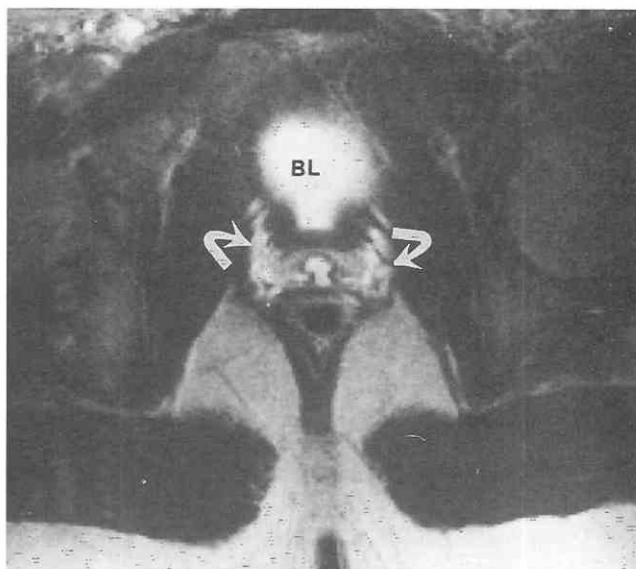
Normal male pelvis. Transaxial T2-weighted fast spin-echo MR image (2500/90) through the pubic symphysis in a 14-year-old boy shows the high-signal-intensity peripheral zone (curved arrows) of the prostate and the lower-signal-intensity central gland. BL, bladder.
